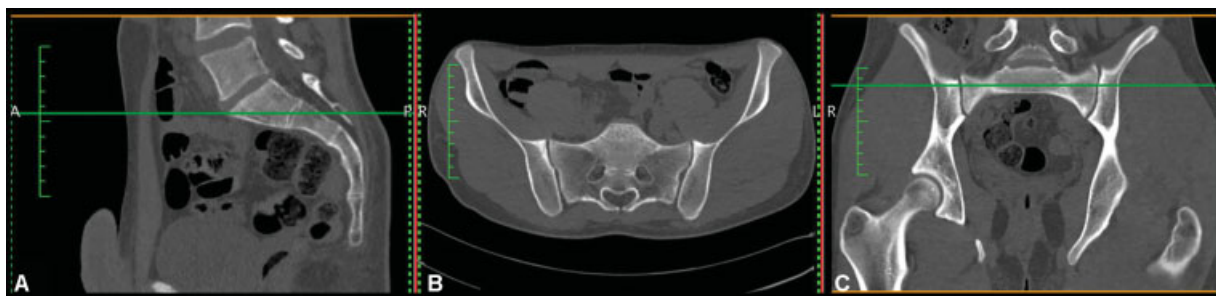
Computed tomography images in (A) Sagittal reconstruction, (B) Axial plane and (C) Coronal reconstruction.
